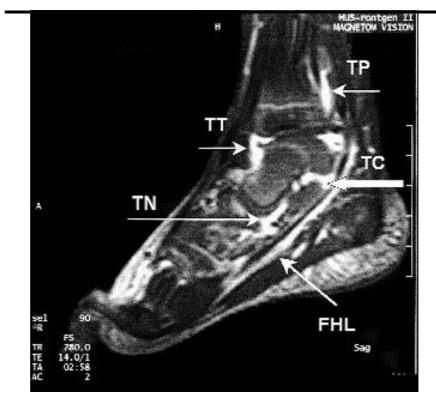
Medial view of the left tarsal region of the 2.8-year-old girl with persistent oligoarthritis. Increased gadolinium uptake into inflamed synovium and tendon sheaths in a T1-weighted sagittal plane in tibiotalar (TT), talocalcanear (TC), talonavicular (TN) joints and sheaths of flexor hallucis longus (FHL) and flexor tibialis posterior (TP) tendon.
